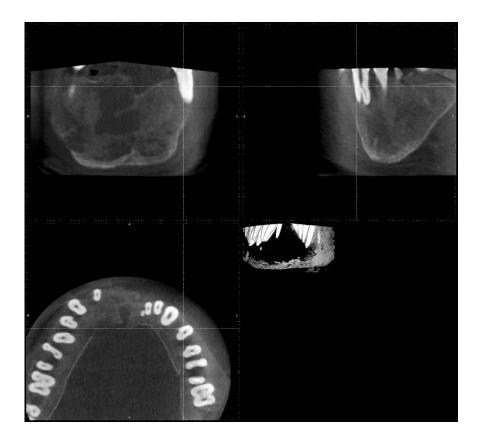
MRI cystic restructuring of the lower jaw, in some areas complete destruction of the bone with pathological thinning of the lower jaw, free sagging of the roots of the teeth of the lower jaw.
